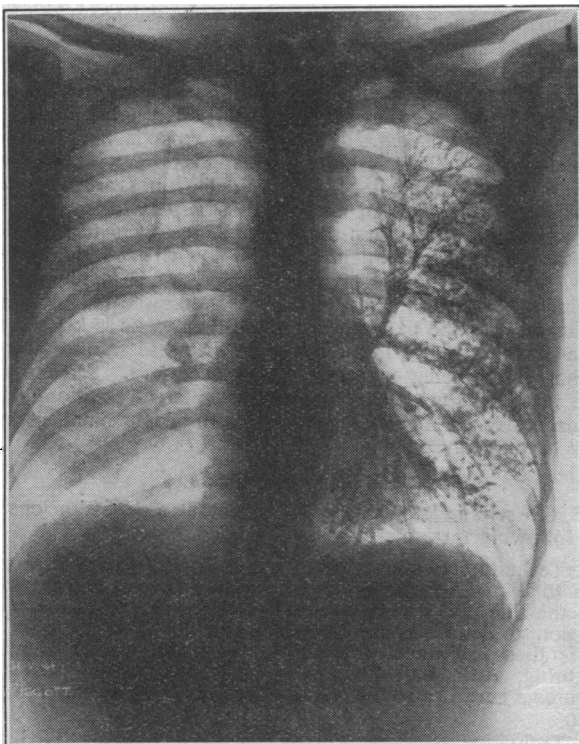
Radiograph showing outlines of the left side of chest.
